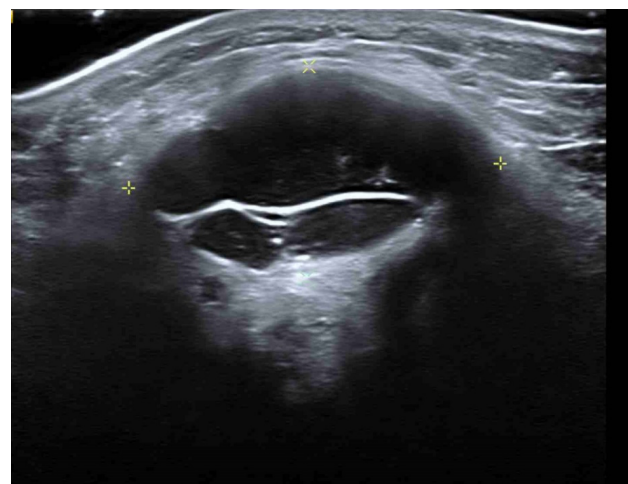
Musculoskeletal ultrasound of the right knee (Siemens Acuson S-2000MT device, 18 MHz transducer, longitudinal view): presence of an hypoechoic lesion with well-defined borders and internal septation, in the internal side of the knee, medially located to internal meniscus, with 3.52 x 2.00 cm, suggestive of a cystic lesion.
